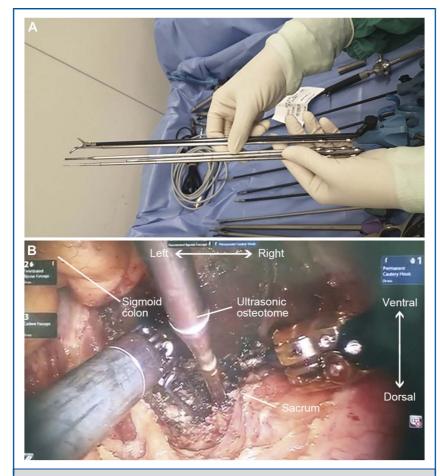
A, The ultrasonic osteotome was specially designed for robotic surgery and matched robotic arms. B, The ultrasonic osteotome was used to create a bony window during robotic-assisted neurogenic sacral tumor resection.
